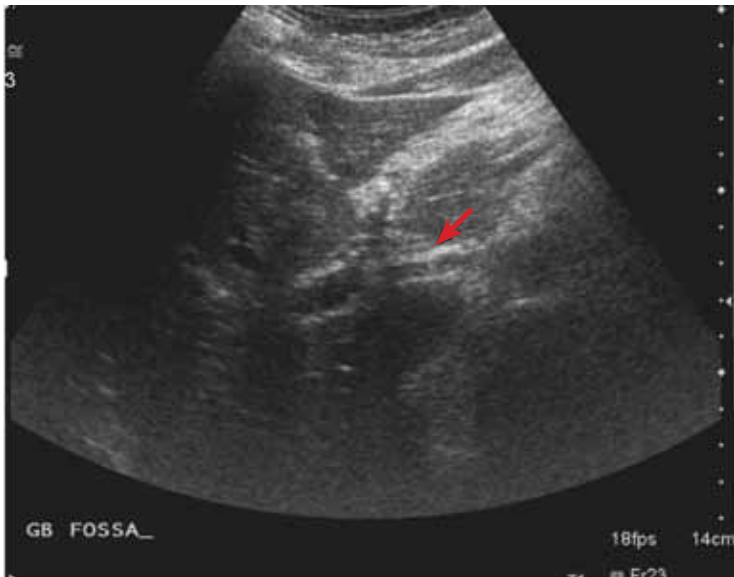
Ultrasonography of the right upper quadrant shows a nondilated common bile duct 4 mm in diameter (arrow). No stones are visible.
